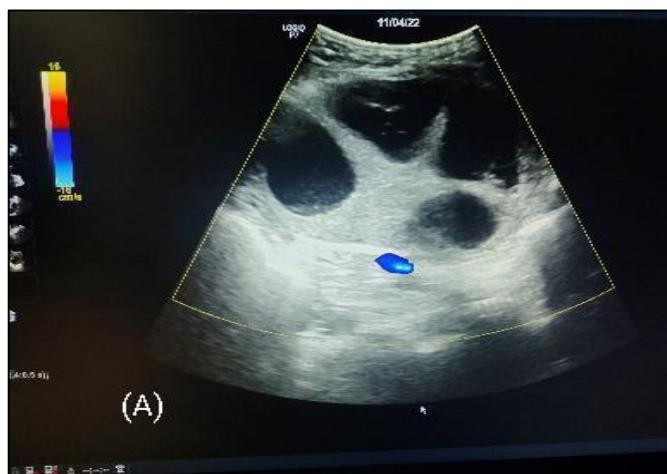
A, B, C: Ultrasound Pictures of OHSS
